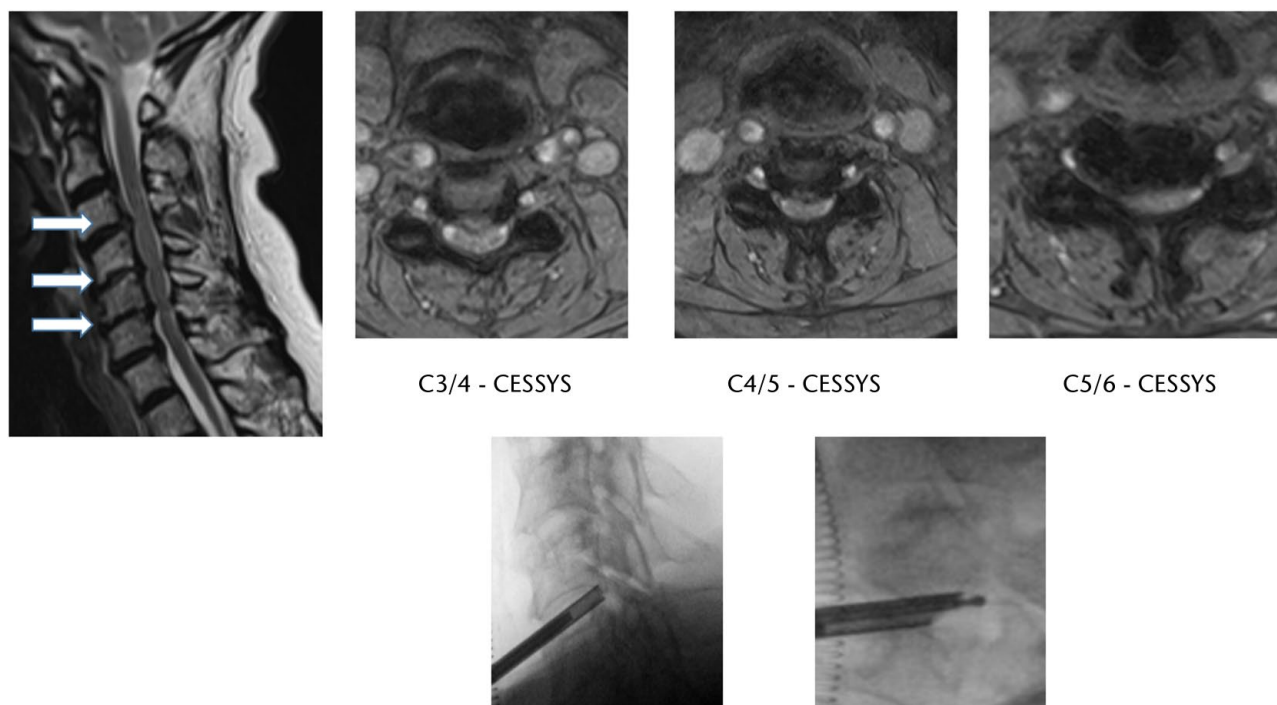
Severe central canal narrowing and multilevel cervical exit foraminal stenosis most prominent at C3/4, C4/5, C5/6 (axial T2-MRI). Lateral and oblique image intensifier radiographs showing positioning of cannula/scope and diamond reamer (CESSYS, Cervical Endoscopic Surgical System).
